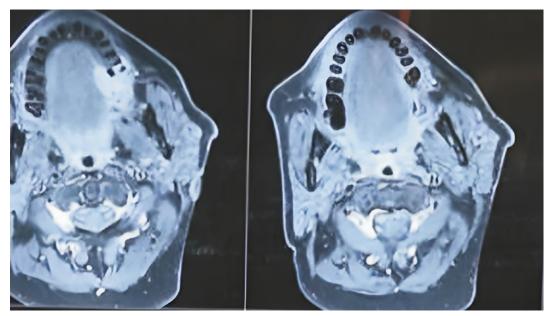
MRI scan showing lesion
